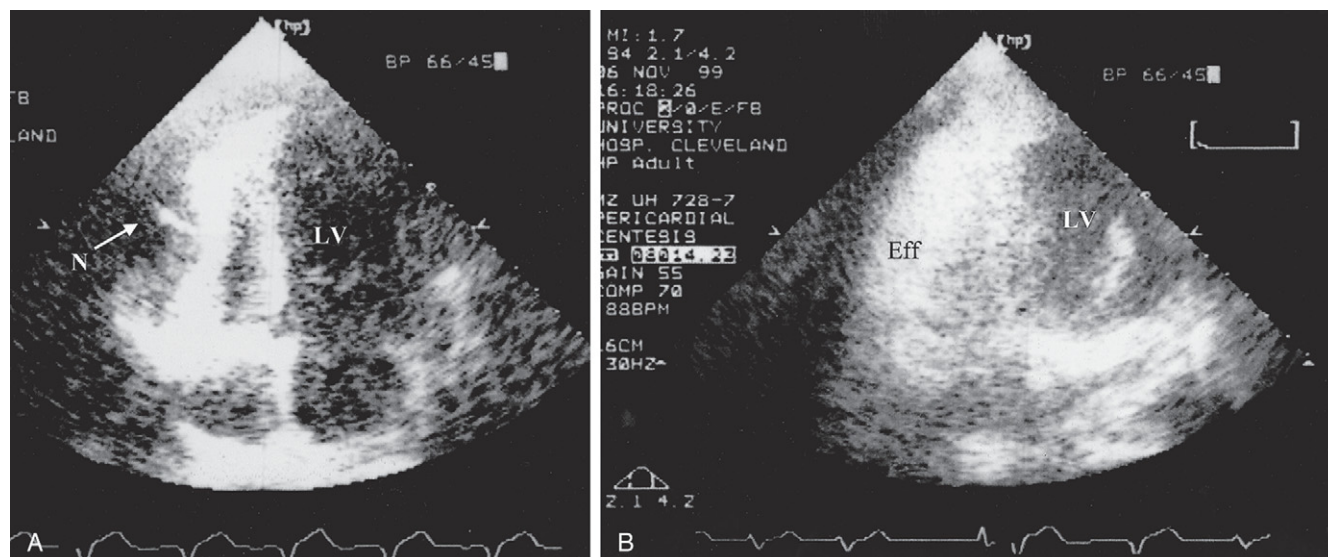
Echocardiographic imaging can be used to verify the intrapericardial location of the needle (N) by either direct imaging (A), or by the production of an intrapericardial contrast effect (Eff) after injection of agitated saline (B). LV, left ventricle.
